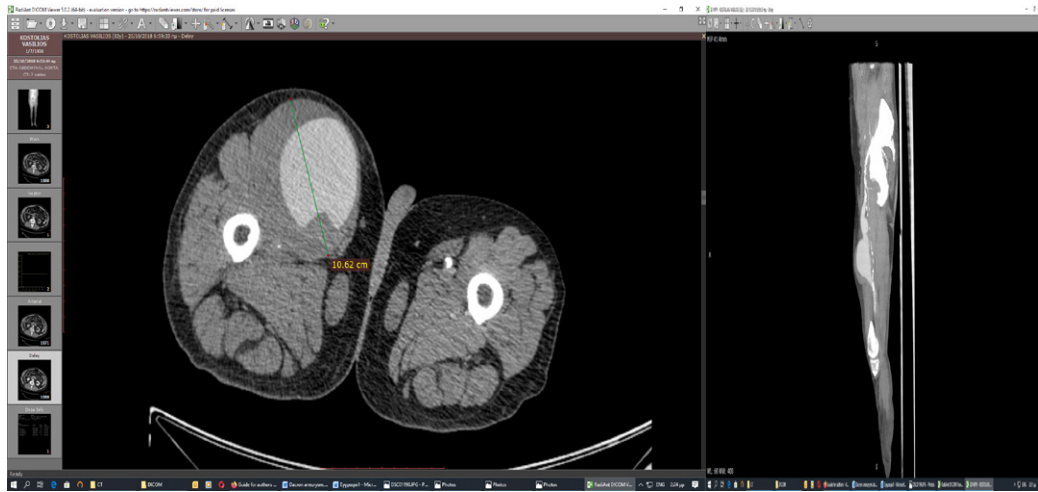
CTA depicting a 106 mm in diameter aneurysm in the middle of a femoral-popliteal bypass graft with the graft being patent.
